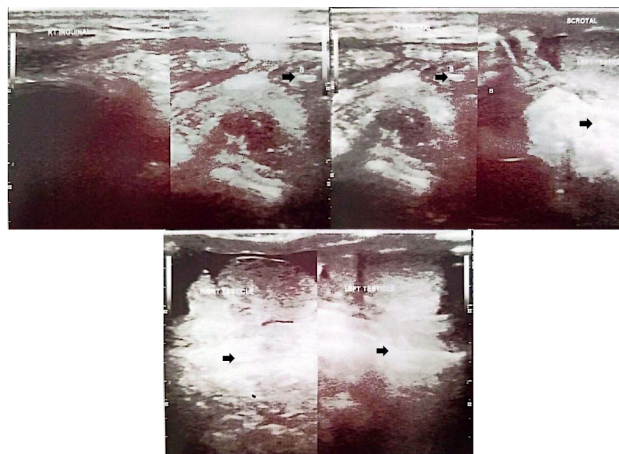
Inguinal USG. Ultrasonographic image of the inguinal and scrotal regions demonstrating both testes with normal size and echotexture located within the scrotal sac (arrows: testicles)
